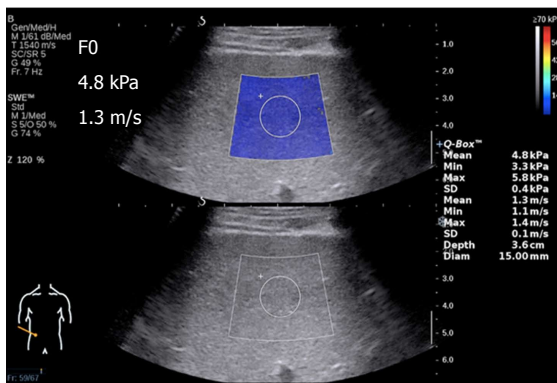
Example of two-dimensional shear wave elastography of the liver implemented using the Aixplorer US system (SuperSonic Imaging, France), which can be displayed simultaneously with the B-mode image. A 2D-SWE image from a 42-year-old male who had normal liver function with liver biopsy-proven fibrosis at METAVIR stage F0. The rectangular box is the area of view where the shear wave measurements were made and color-coded. The round circle is the ROI where the measurements were obtained. The system provides the mean, Max, Min, SD and Diam of the stiffness measurements within the ROI. For this case, the following measurements were made: Young's modulus: Mean = 4.8 kPa, Min = 3.3 kPa, Max = 5.8 kPa, SD = 0.4 kPa; shear wave velocity: Mean = 1.3 m/s, Min = 1.1 m/s, Max = 5.8 m/s, SD = 0.1 m/s, Depth = 3.6 cm, and Diam = 15.0 mm. 2D-SWE: Two-dimensional shear wave elastography; Diam: Diameter; Max: Maximum; Min: Minimum; ROI: Region of interest; SD: Standard deviation; US: Ultrasound.
